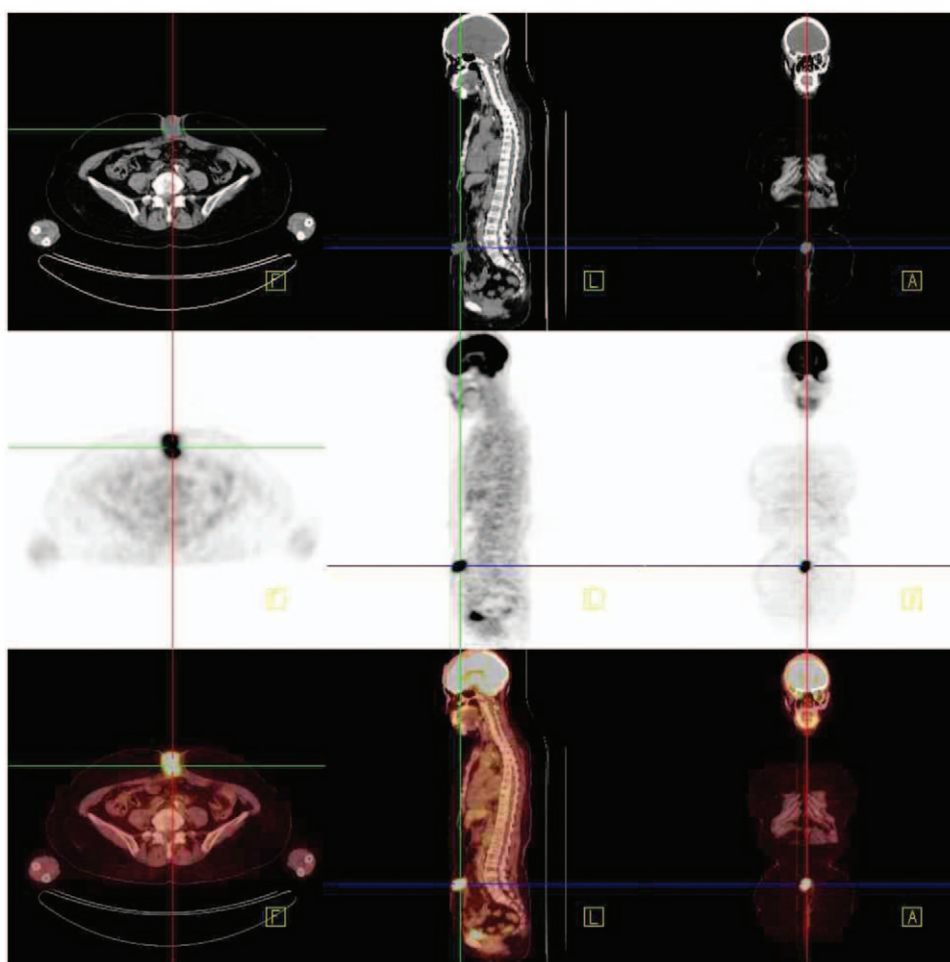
The follow-up positron emission tomography/computed tomography 582, days after diagnostic laparoscopy showed a $3.3 \times 2.8 \times 2.8 \text{ cm}^3$ abdominal wall mass at the umbilical port site.
